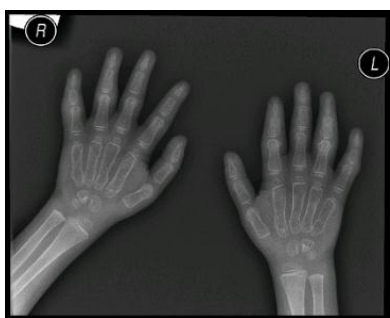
Radiograph at age 4 years, showing generalized osteopenia and cortical thinning.
